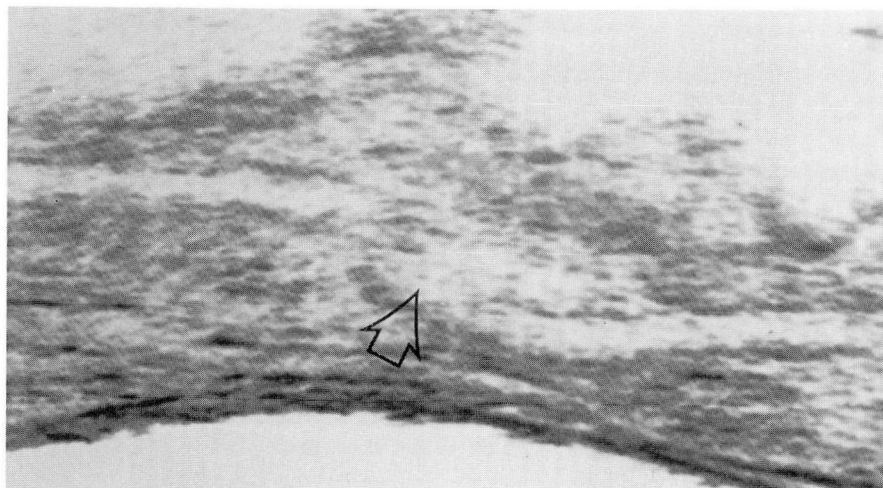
Sagittal ultrasonogram of the right leg. Note mass (arrow) and interruption of the arterial lumen. Patient is supine; head is to the left.
